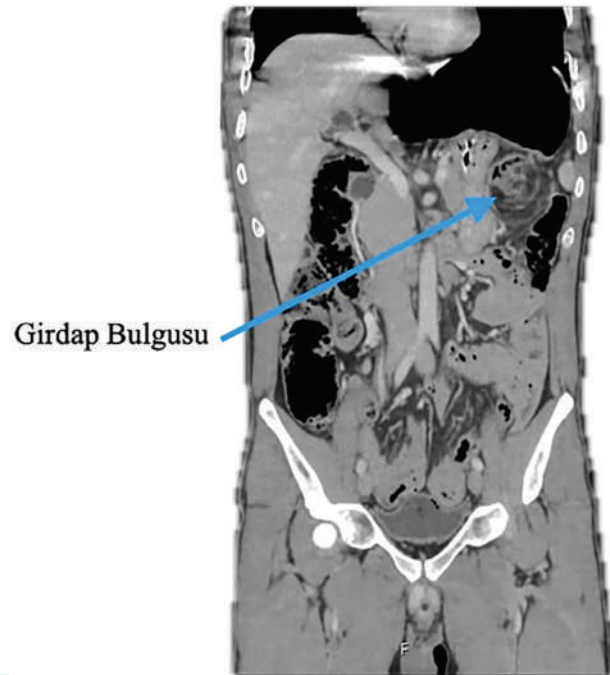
Whirl sign on CT imaging.
